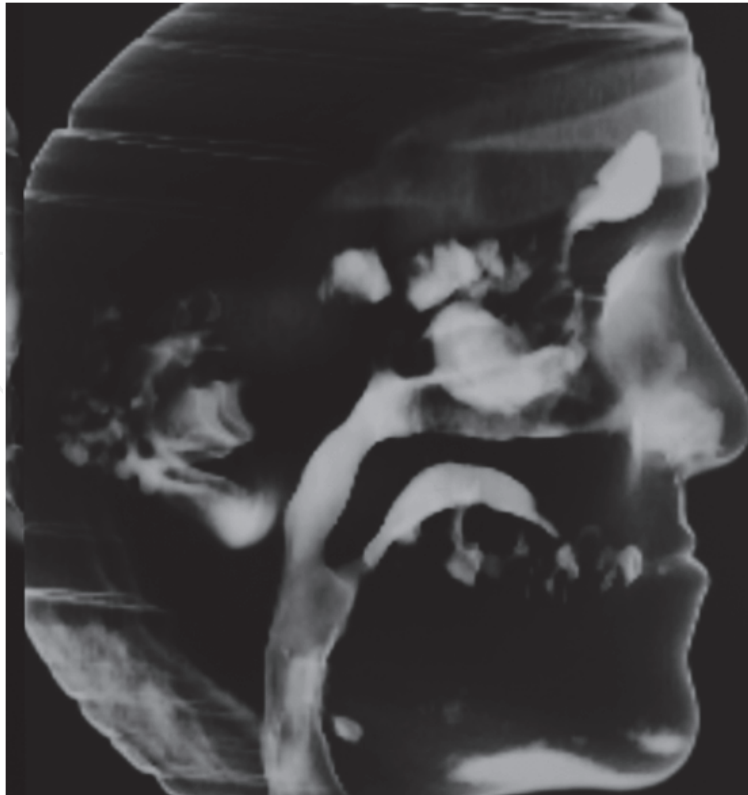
Airway assesment on CBCT
